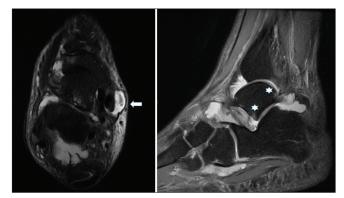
Marked fluid distension and synovial thickening with distension of the common peroneal tendon sheath into the peroneus brevis and peroneus longus sheaths (arrow), reactive subcortical bone marrow edema along the anterior and posterior aspect of the talus (*) and intraarticular effusion. Sagittal (left) and axial (right) T2-weighted fat-saturated magnetic resonance image
